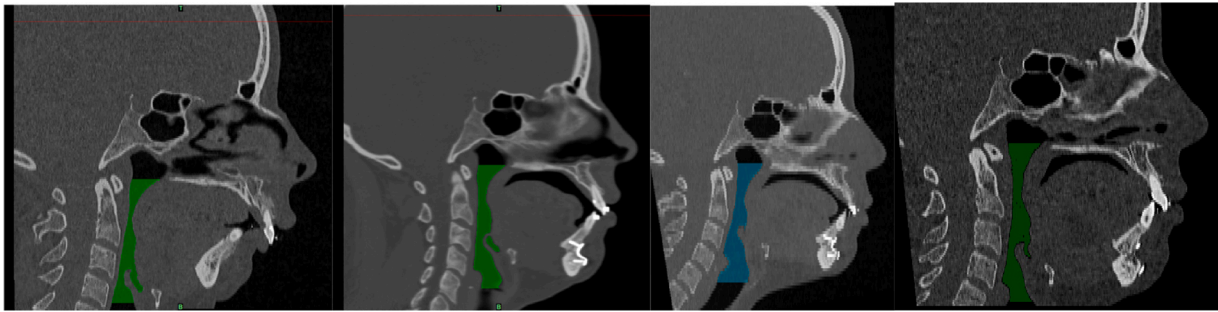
CT in sagittal section showing comparative pre-surgical airway (8.1) and post-surgical airway at 3 (8.2), 6 (8.3) and 9 months (8.4).
